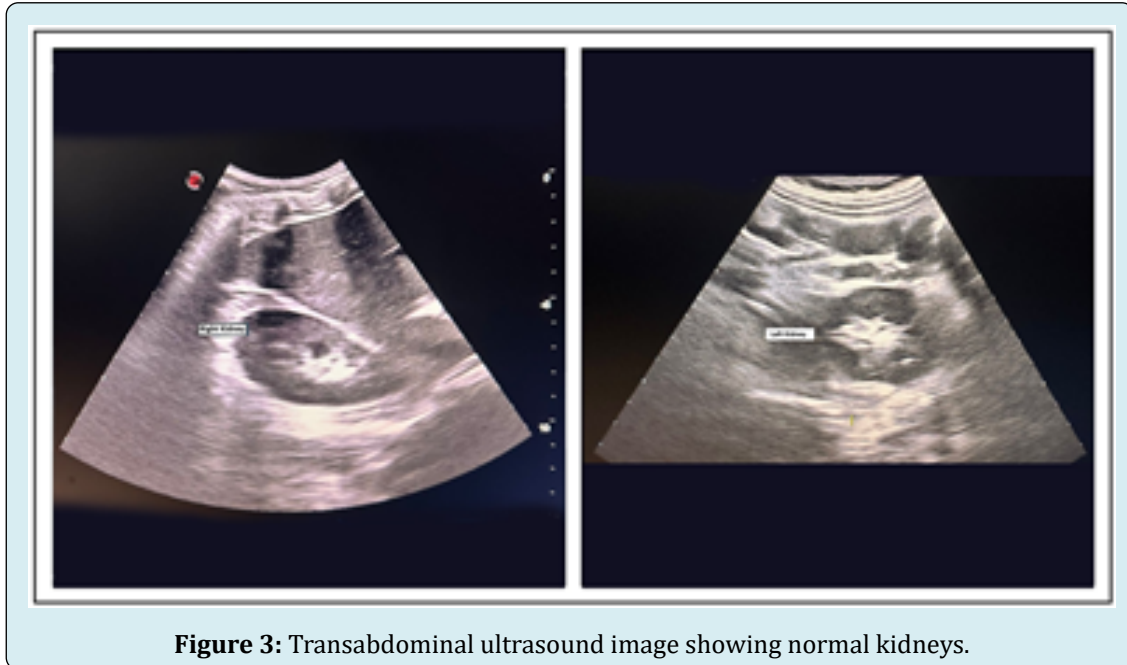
Transabdominal ultrasound image showing normal kidneys.
